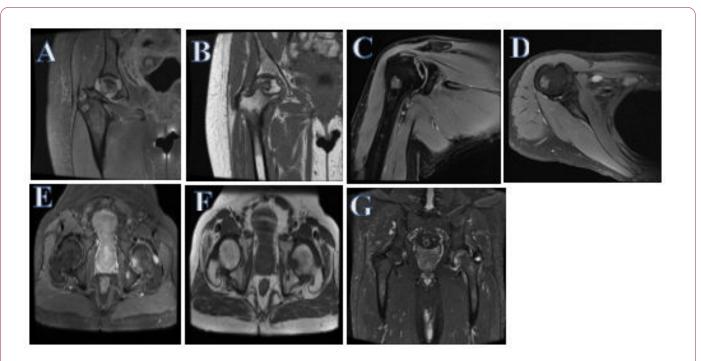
(A,B) Area of avascular necrosis is noted in the MRI of the right femoral head measuring about 3.2 cm in addition to two bone infarcts in the major trochanter of the femur measuring about 1 cm and 9 mm. Mild bone marrow oedema is noted in the right femoral head and proximal femoral bone. (C,D) MRI of the right shoulder for the same patient showing Focal area of avascular necrosis in the inner margin of the humeral head. Additionally, multiple enlarged lymph node in the right axilla was noted. (E-G) hip MRI of a different patient, showing early avascular necrosis of the left femoral head with flattening, irregularity and a large cyst. Additionally, there is evidence of diffuse osteoarthritic changes involving both hip joints, with decreased joint space on the left side. (Curtsey: Dr F Alalawi, Department of Nephrology, Dubai Health Authority, Dubai, UAE).
